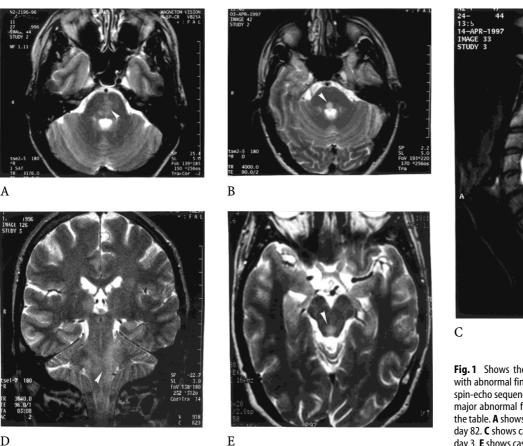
Shows the MRI images of those 5 patients with abnormal findings. All images are T2-weighted spin-echo sequences. White arrowheads point to the major abnormal findings as described in the text or the table. A shows case 3 on day 8. B shows case 4 on day 82. C shows case 5 on day 54. D shows case 6 on day 3. E shows case 8 on day 3.
